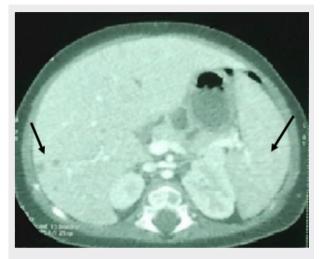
Abdominal computed tomography scan: Enlarged liver and spleen with multiple hypodense lesions.
